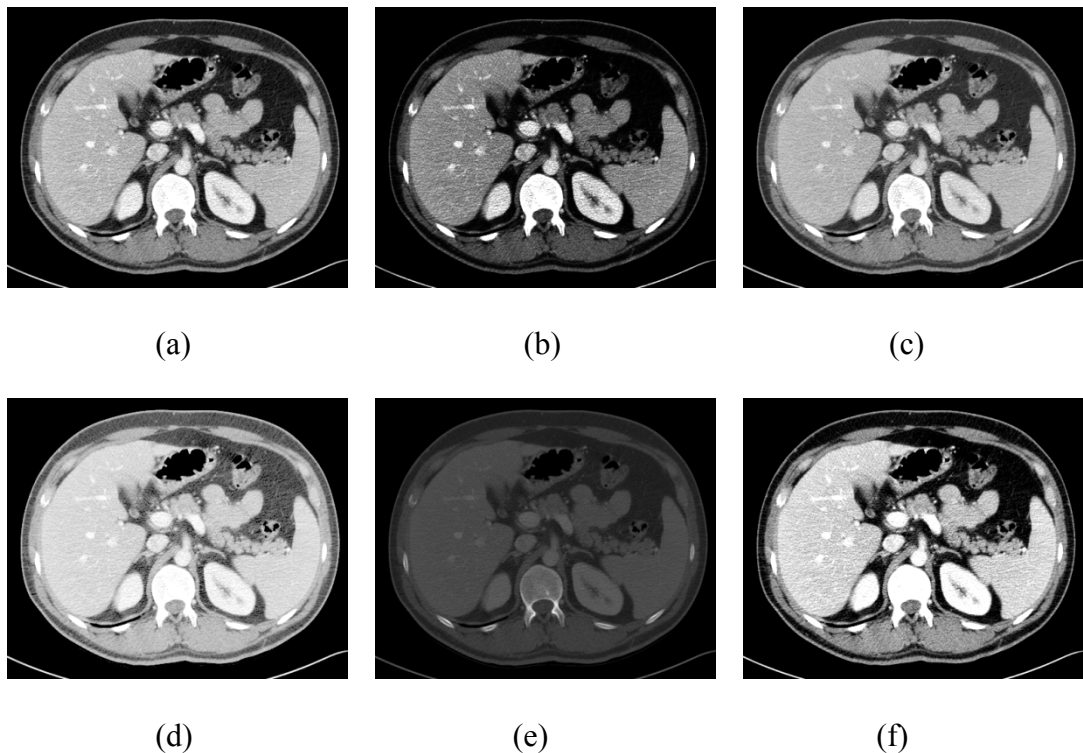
Different Window Level and window width adjustments for an abdominal CT image (a) original (b) square LUT (c) logarithmic LUT (d) square root LUT (e) windowing presets for bones (f) windowing presets for mediastinum.
